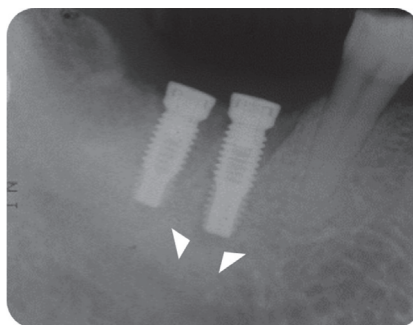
Periapical radiograph revealed a radiolucency at the implant of mandibular right first molar site two weeks after the first stage surgery. Arrow heads depict the extent of IPL.
